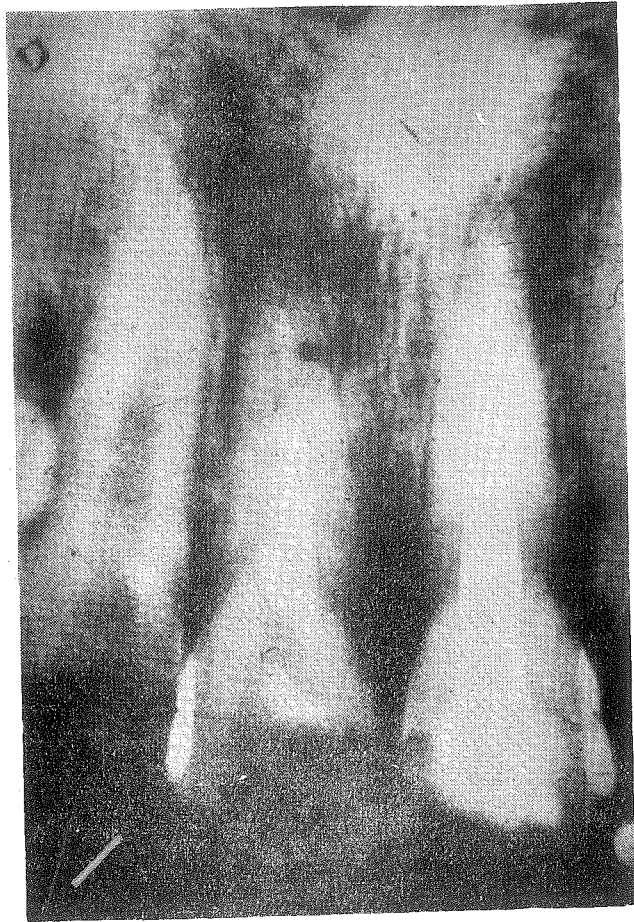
X-ray taken immediately after the canal of the upper jaw incisor was filled with copper amalgam.
